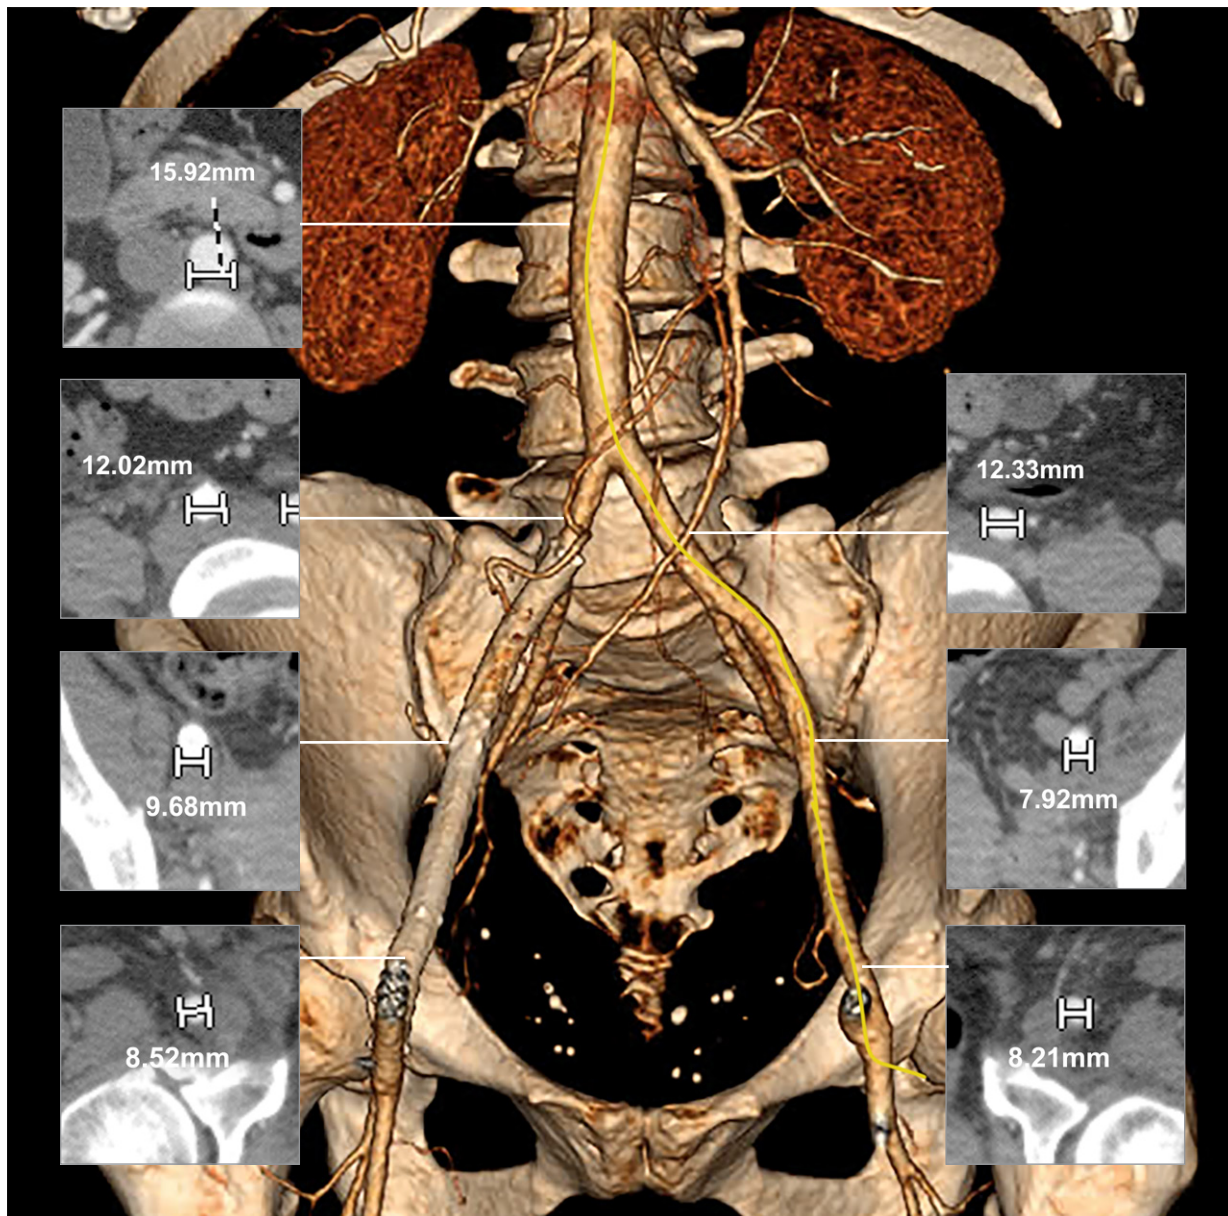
Preprocedural abdominal and pelvic computed tomographic angiograms, in 3-dimensional multiplanar reconstruction (main image) and axial views (insets) enabled evaluation of vessel size, disease status, tortuosity, and possible vascular disease. The planned access site, the right common femoral artery (diameter, 8.52 mm), had no substantial disease or calcification. Yellow line indicates the centerline of the aorta and the left common and external iliac and common femoral arteries.
